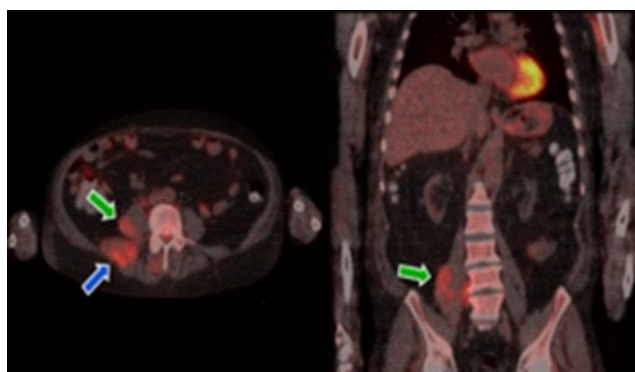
Patient with spondylodiscitis of L4-L5 and epidural abscess at MRI. Fluorine-18-FDG PET/CT: typical ^{18}F -FDG uptake in L4-L5 due to spondylodiscitis and unexpected uptake in longissimus muscle and in psoas major muscle as complication (green arrows).
